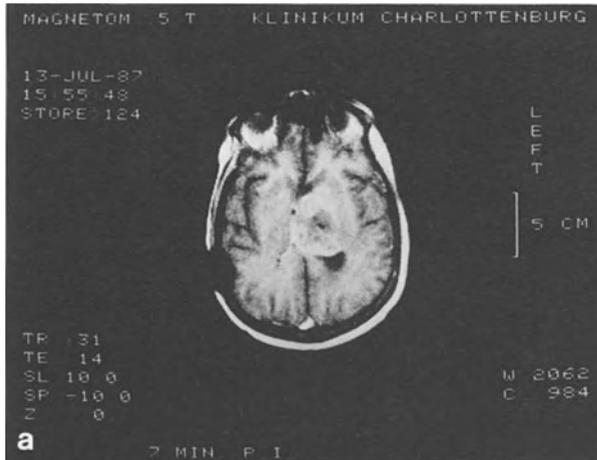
a Axial MRI in a 38-year-old man suffering from headache. In the left thalamic region a cystic tumor is detectable, characterized by stereotactic biopsy as a glioblastoma. b rCBF measurement with HMPAO SPECT in the same patient shows an increased tracer uptake in the tumor area (hyperperfusion)
